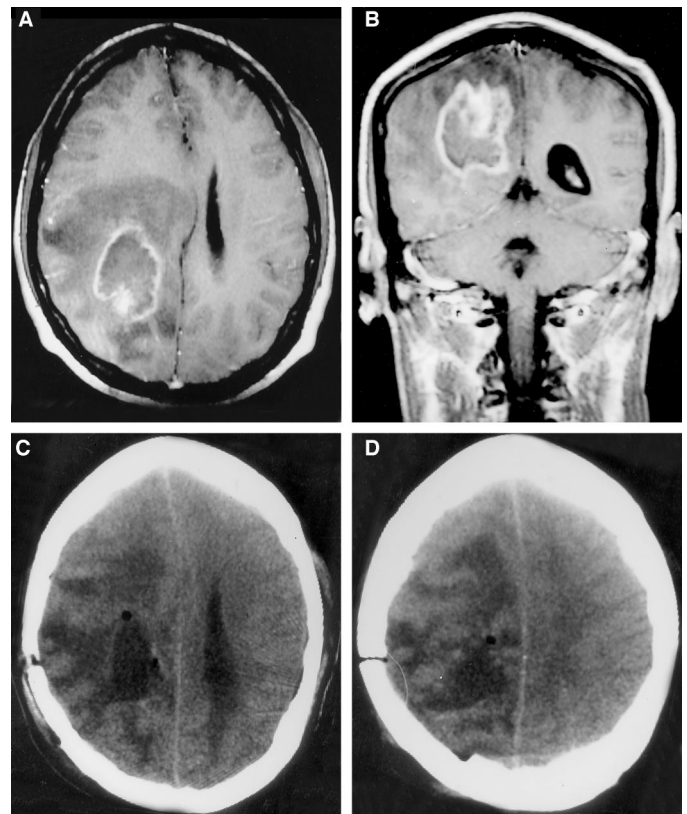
A, post-gadolinium T1-weighted axial MRI scan showing a mass lesion located in the right parieto-occipital region with peripheral ring enhancement and central nonenhancing area. The mass with perifocal edema is producing significant mass effect and midline shift. B, gadolinium-enhanced T1-weighted MRI scan of the same patient, showing the same lesion in coronal view. The lesion has irregular margins and it obliterates the ipsilateral lateral ventricle. C and D, postcraniotomy non-enhancing axial CT scans of the same patient, showing significant edema and mass effect. This patient's condition deteriorated rapidly after surgery. The patient died within 1 week of surgical intervention.
